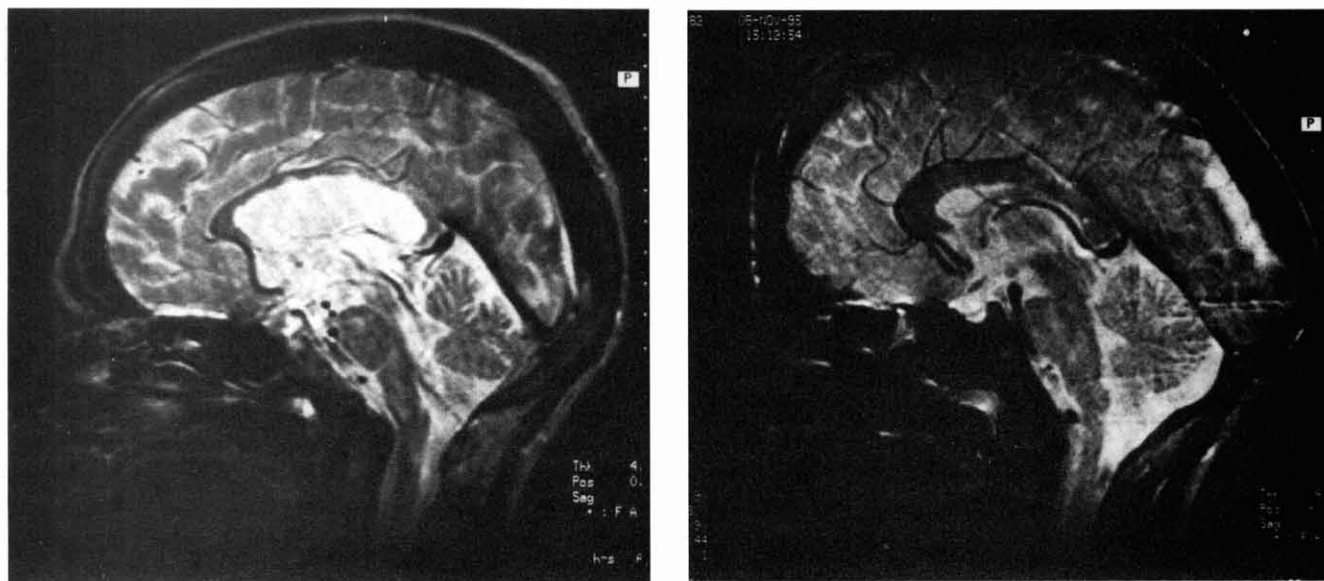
T2-weighted images, sagittal plane. A, atrophy of the corpus callosum. B, normal corpus callosum.
